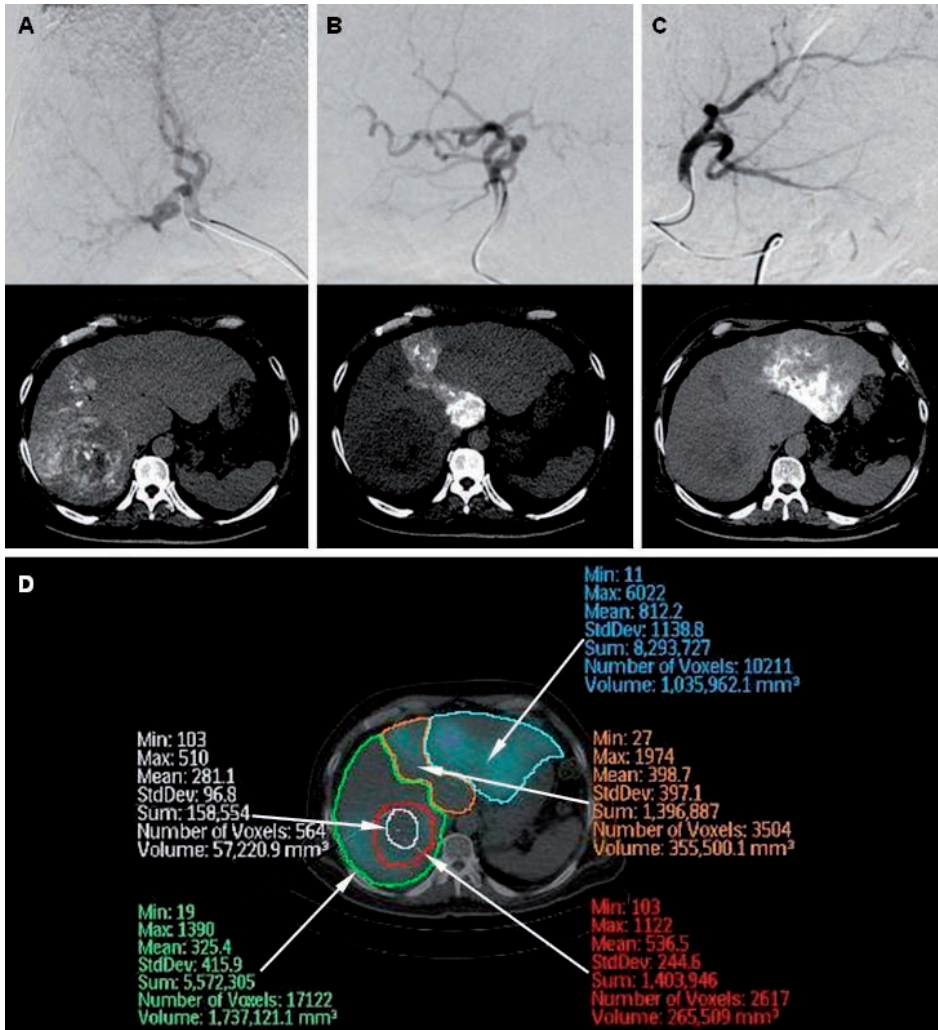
Example of artery-specific SPECT/CT partition modeling of 3 arterial territories. A liver with multifocal HCC supplied by the right (A), middle (B) and left (C) hepatic arteries is depicted here in digital subtraction angiography and catheter-directed CTHA respectively. Regions-of-interest (ROI) are drawn on ^{99m}Tc-MAA SPECT/CT transaxial slices representing the left (D, blue ROI), middle (D, orange ROI) and right (D, green ROI) hepatic artery planning target volumes, the implanted tumor (D, red ROI) and necrotic tumor (D, white ROI).
